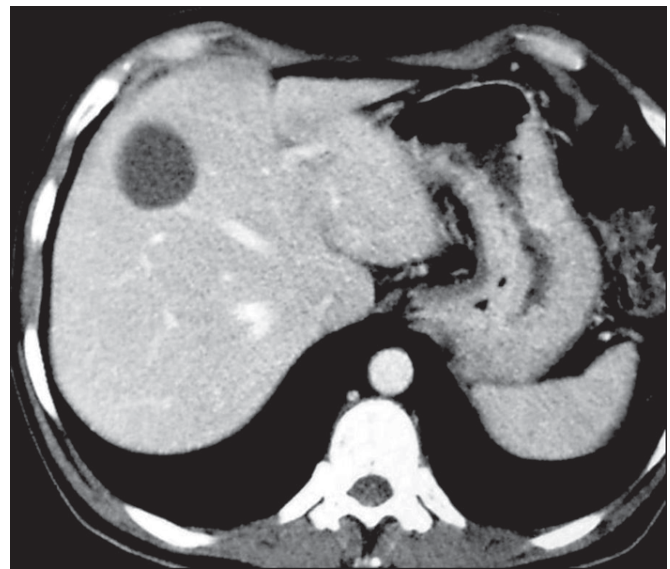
Contrast-enhanced CT shows a well defined, round, unilocular, low-density, non-enhancing lesion suggestive of a simple cyst in the right lobe of the liver.
